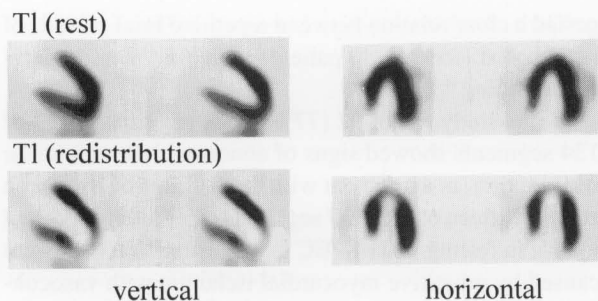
Representative SPECT images with resting ^{201}Tl (Patient 1 in Table 1). RR of ^{201}Tl is observed at the apical portion of left ventricle.
